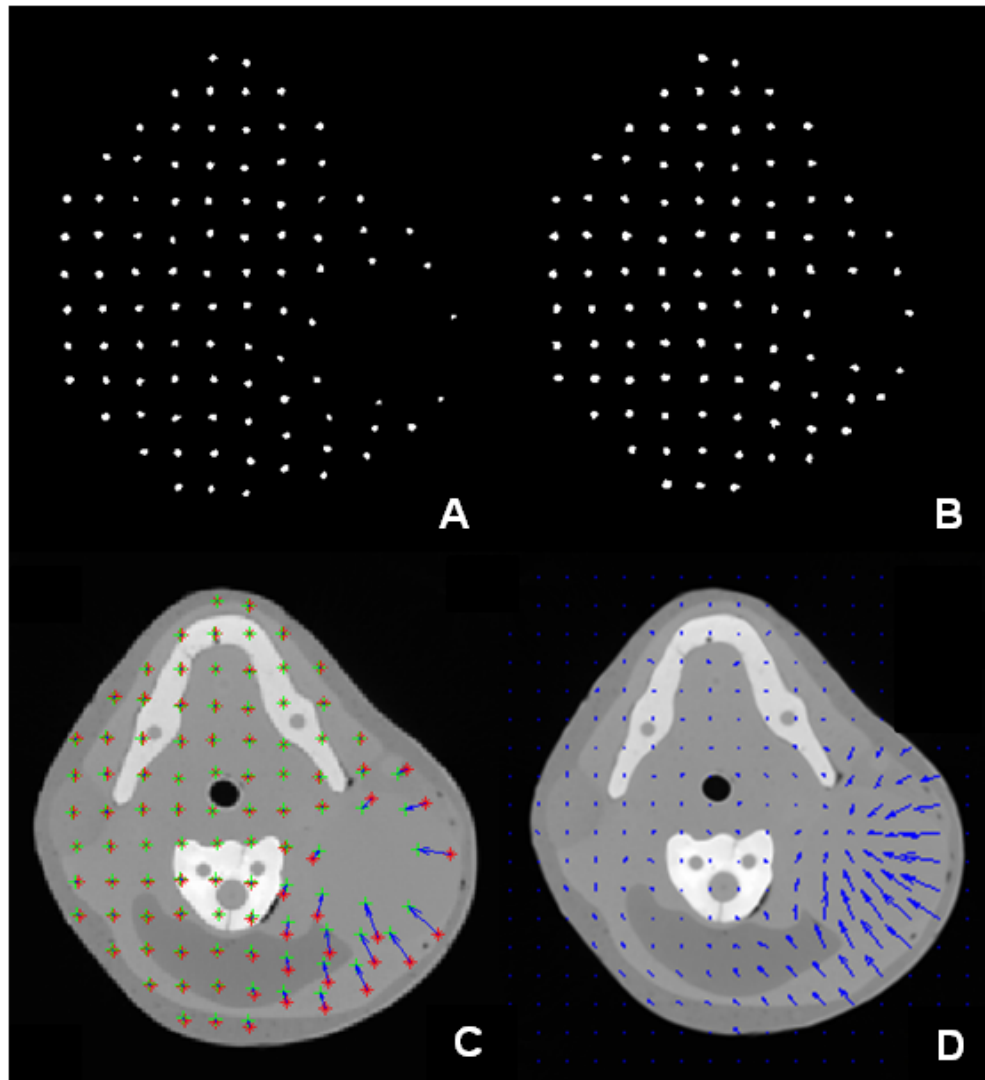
(A) Initial marker positions. (B) Final marker positions. (C) Initial and final marker position with the measured deformations overlaid on the reference CT image. (D) Generated deformation vector field overlaid on the reference CT image.
